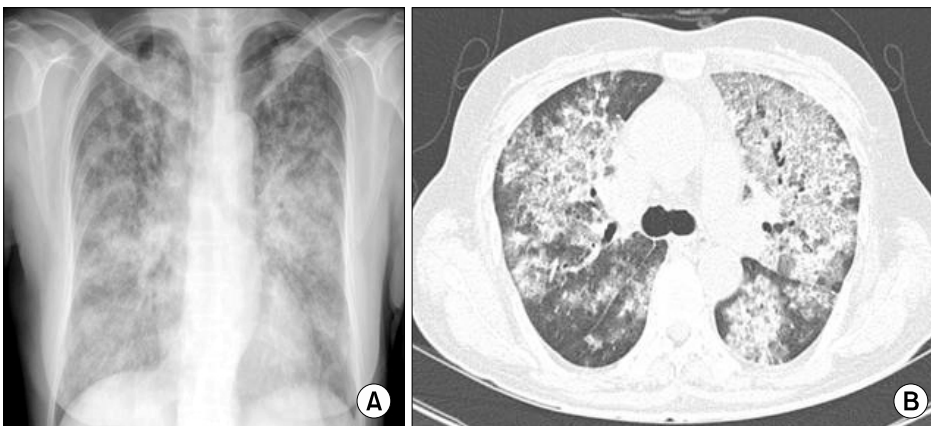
Diffuse consolidation and ground glass opacity are observed on both lungs of initial chest X-ray (A). Initial chest computed tomography shows bilateral involvement of diffuse ground glass opacity, interlobular septal thickening, and multifocal consolidations (B).
